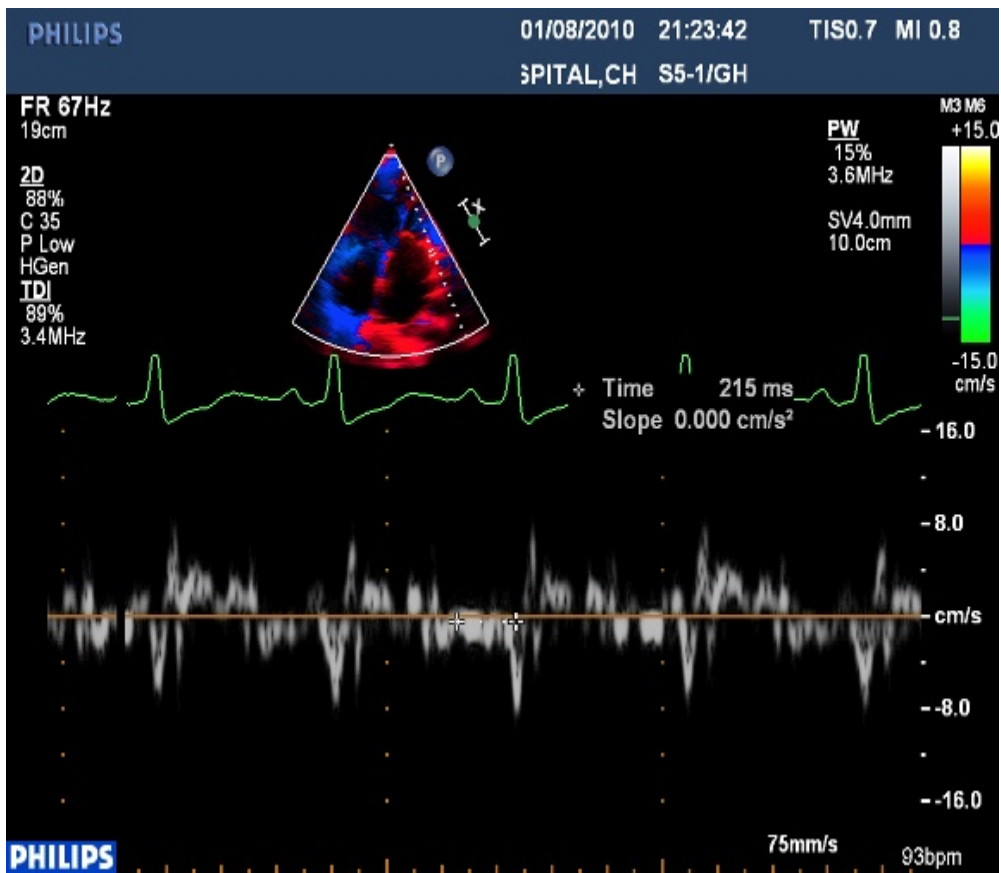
Shows the measurement of PA-TDI interval by tissue Doppler imaging
